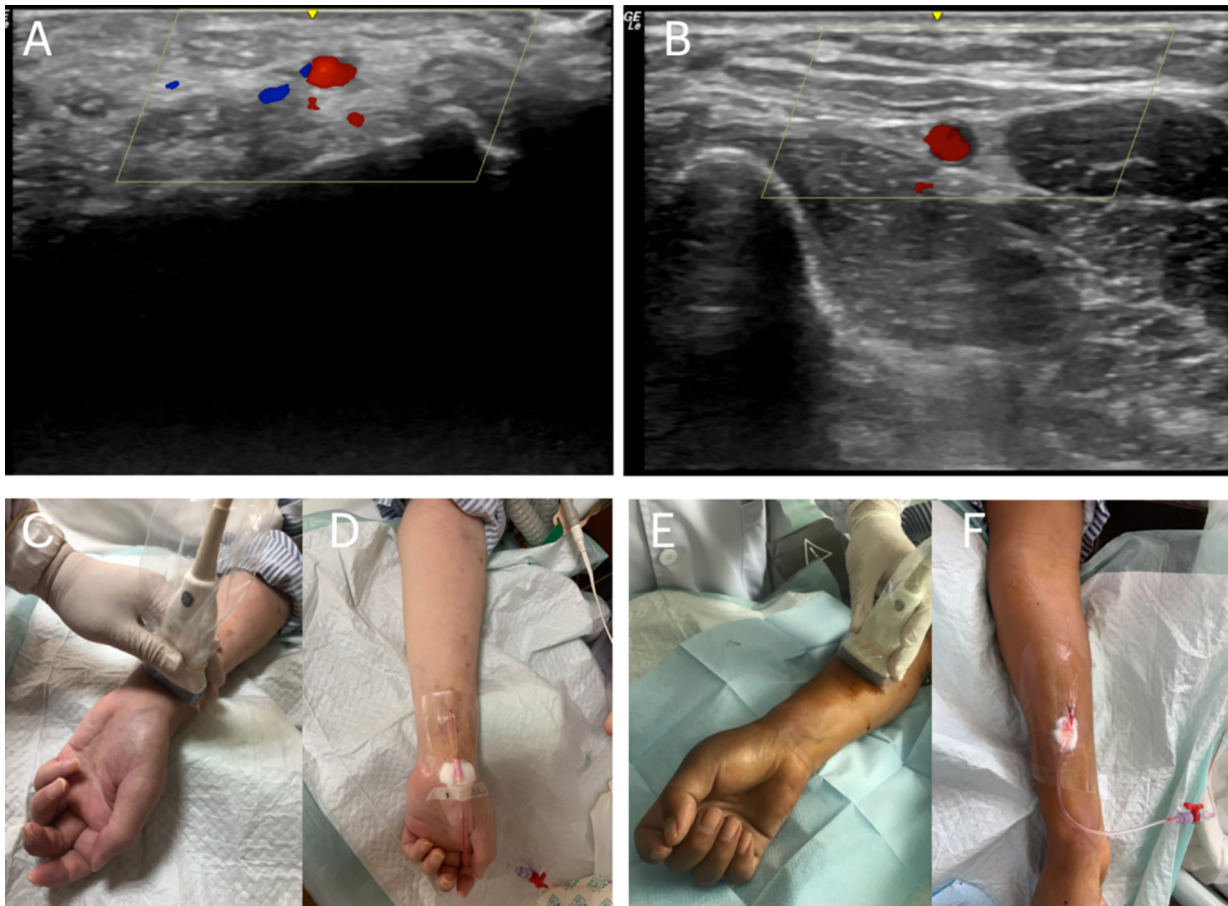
Ultrasound-guided radial artery catheterization. A, Short-axis view of the radial artery at the wrist level displaying arterial blood flow. B, Short-axis view of the radial artery at the mid-forearm level displaying arterial blood flow. C, Radial artery at the wrist localized by ultrasound. D, Radial artery catheterization at the wrist level. E, Radial artery in the mid-forearm localized by ultrasound. F, Radial artery catheterization at the mid-forearm level.
